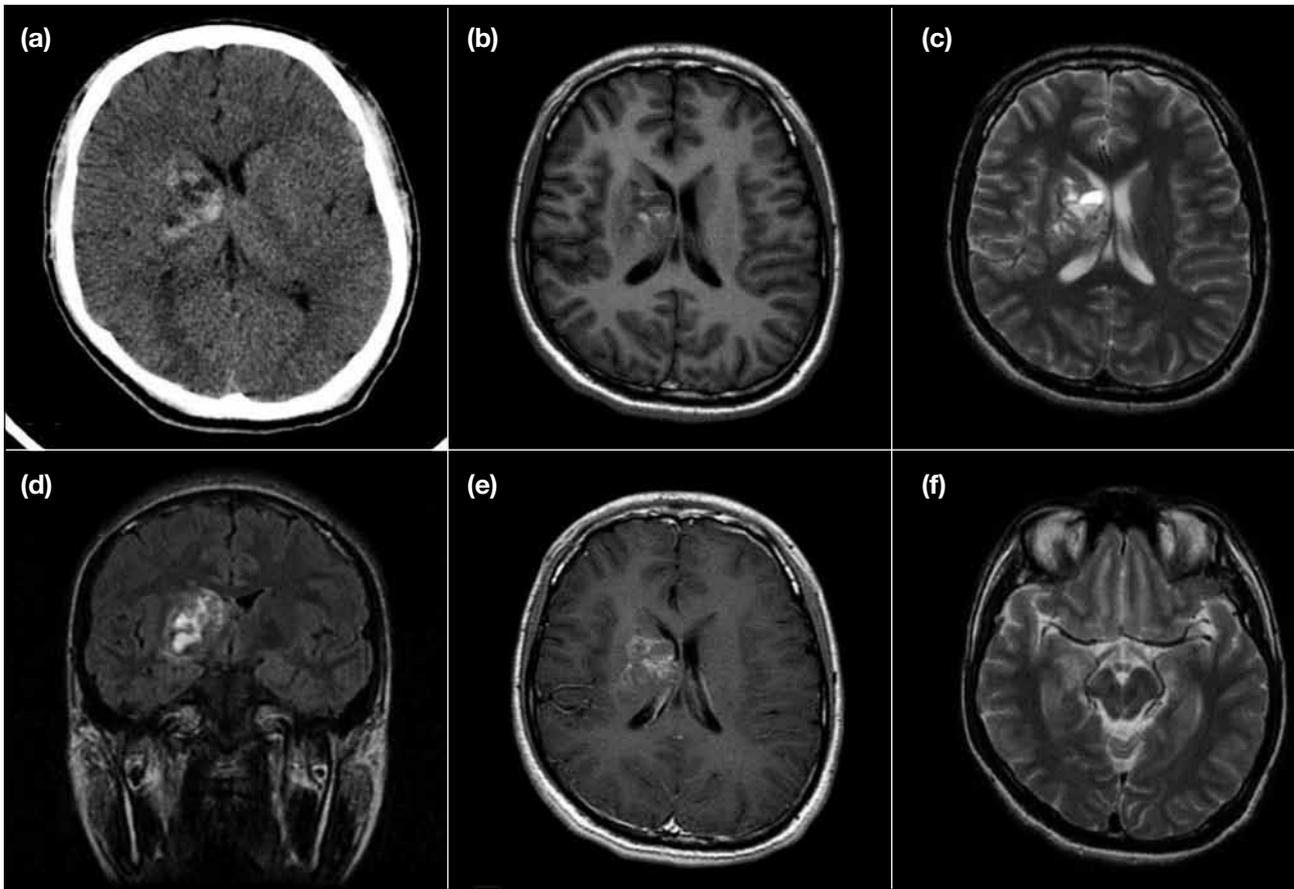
Case 1. 19-year-old male patient. (a) Computed tomography of the brain showed mixed hypodense and hyperdense lesion in right basal ganglia with mild mass effect onto ipsilateral frontal horn. (b) Axial T1-weighted; (c) T2-weighted; and (d) fluid-attenuated inversion recovery magnetic resonance (MR) images confirmed the presence of the lesion with mixed cystic and solid components, together with fluid-fluid levels within the cystic component. (e) Post-contrast T1-weighted MR image revealed patchy enhancement over the periphery of the solid component. (f) Axial T2-weighted MR image at the midbrain level showed a smaller right cerebral peduncle.
